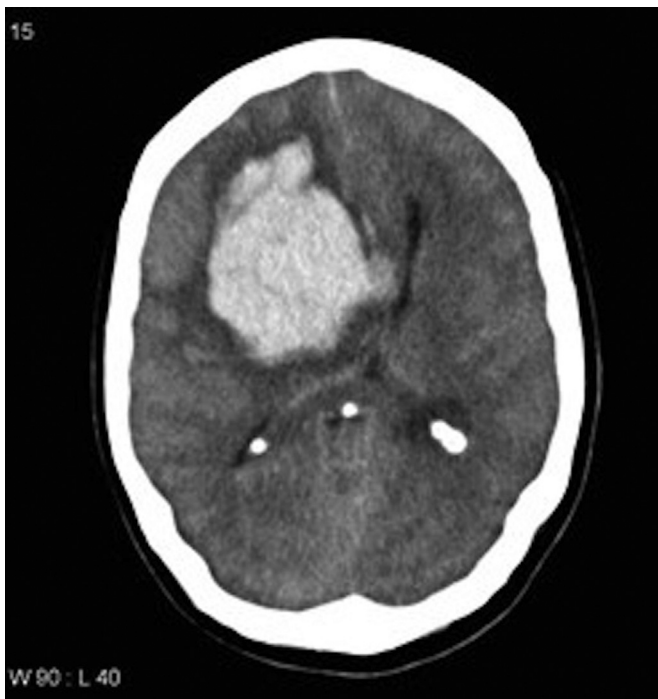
Axial noncontrast head CT scan showing a large lobar hemorrhage in the frontal lobe extending into the ventricles. Source: Reproduced from [Radiopaedia.org](https://radiopaedia.org), rID:10678, case courtesy of Assoc Prof Frank Gaillard, under the Creative Commons Attribution BY-NC-SA 3.0.
